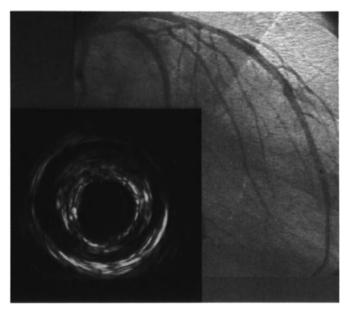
"Normal" angiographic coronary artery. This distal left anterior descending artery is actually quite thickened and diseased (ultrasound inset).
